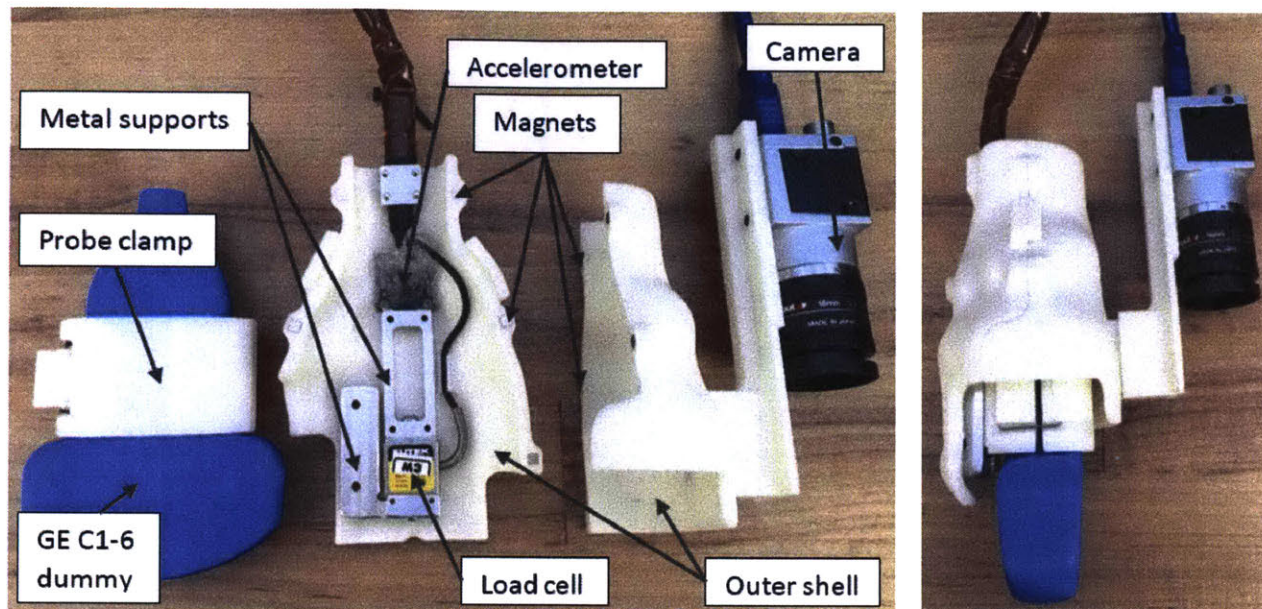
Hardware to record force-correlated ultrasound images and skin images
